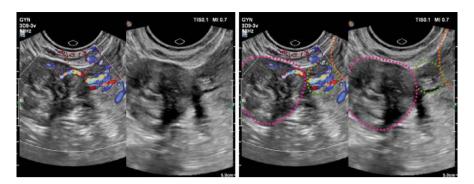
Type 7 fibroid—Left: color Doppler ultrasound shows blood flow from the uterus at the pedicle of the subserosal fibroid. Right: B-mode ultrasound shows the pedicle of the fibroid. The uterus is outlined in orange; the fibroid is circled in pink; the fibroid pedicle is circled in green
